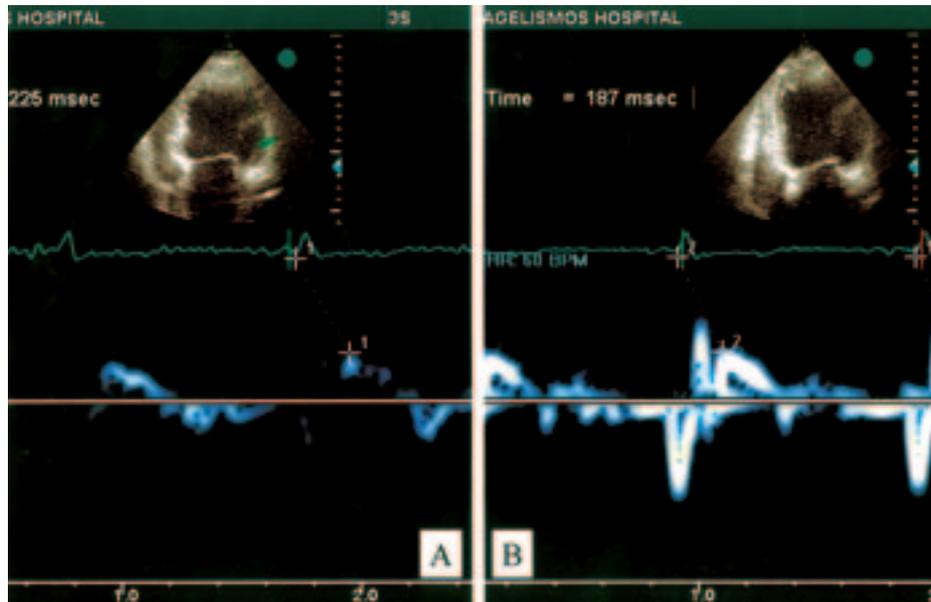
Evaluation of intraventricular dyssynchrony with the aid of tissue Doppler imaging. A: Measurement of the time interval from the onset of the QRS to the occurrence of the peak systolic velocity of the left ventricular lateral wall in the apical four-chamber view (lateral wall T_s). B: Measurement of the time interval from the onset of the QRS to the occurrence of the peak systolic velocity of the interventricular septum (septal T_s). Intraventricular delay is defined as the difference between these two values [lateral wall T_s – septal T_s] and is an index of intraventricular dyssynchrony.
